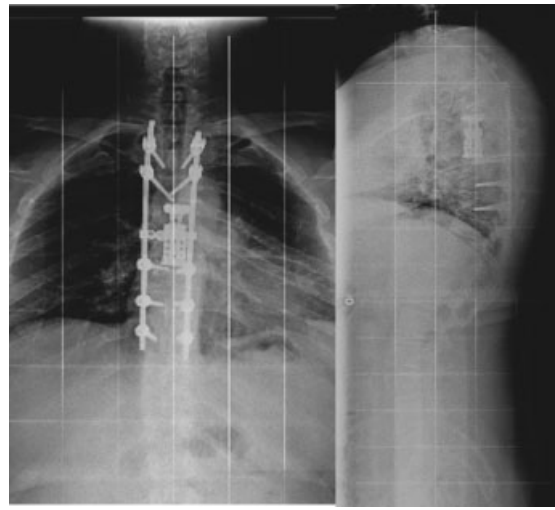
One-year follow-up X-ray scan: good realignment of the spinal column and no other complications.
